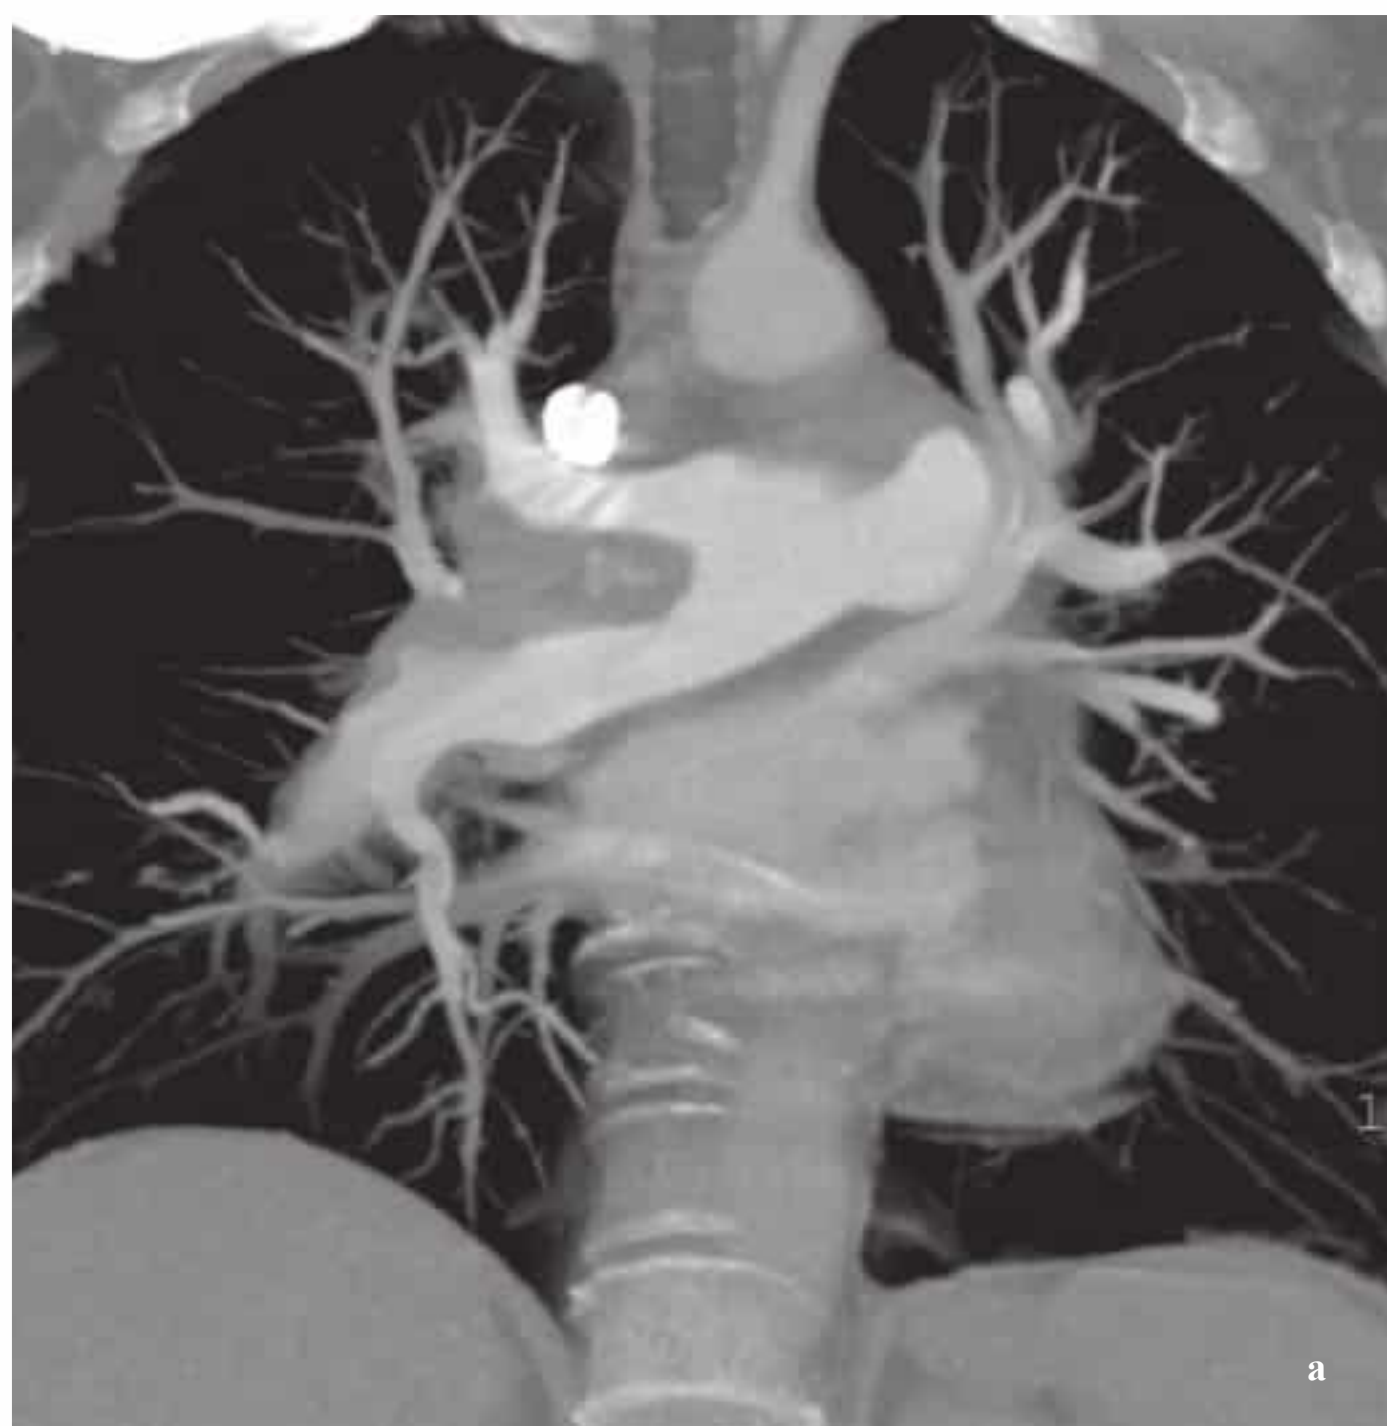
a, b Chronic thromboembolic pulmonary hypertension (CTEPH): CTA and MRA findings.
